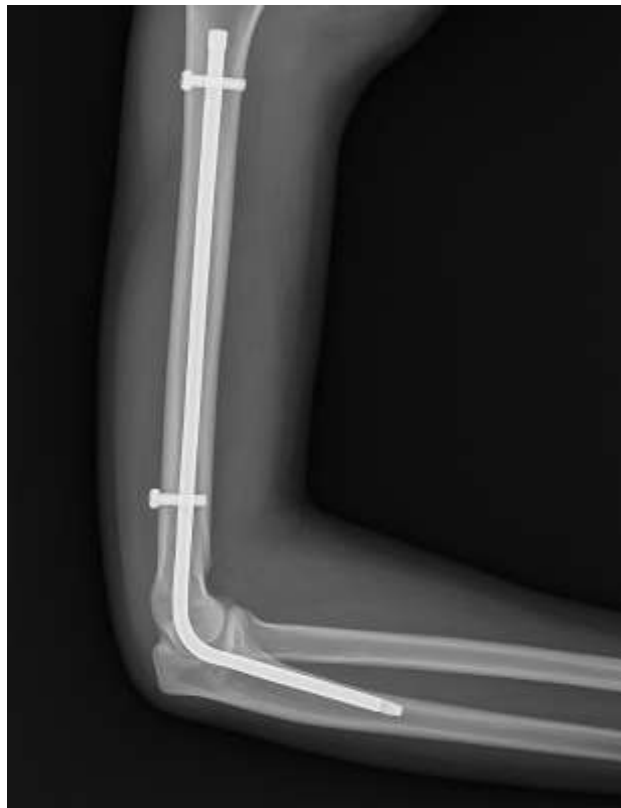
Immediate postoperative X-ray after antegrade interlocking nailing
